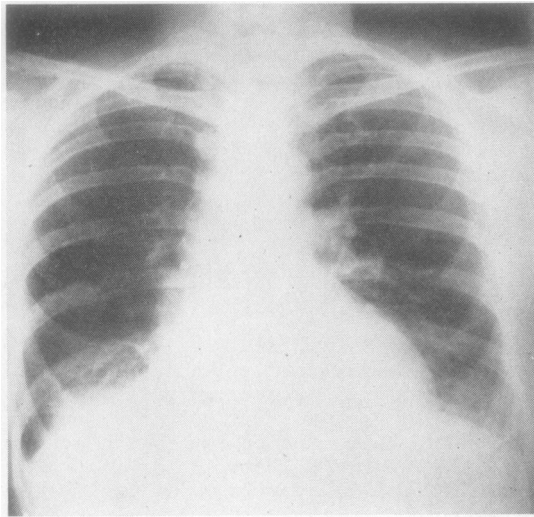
Case 2, May, 1952. Postero-anterior and right lateral radiographs showing collapse and consolidation of the posterior basic segment of the lower lobe of the right lung.
